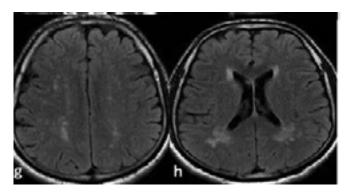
g. Signal pathologies in bilateral parietal localization at the vertex level in FLAIR sequence h. Hyperintense signal pathologies in the deep white matter adjacent to the posterior horn of the bilateral lateral ventricles in FLAIR sequence
